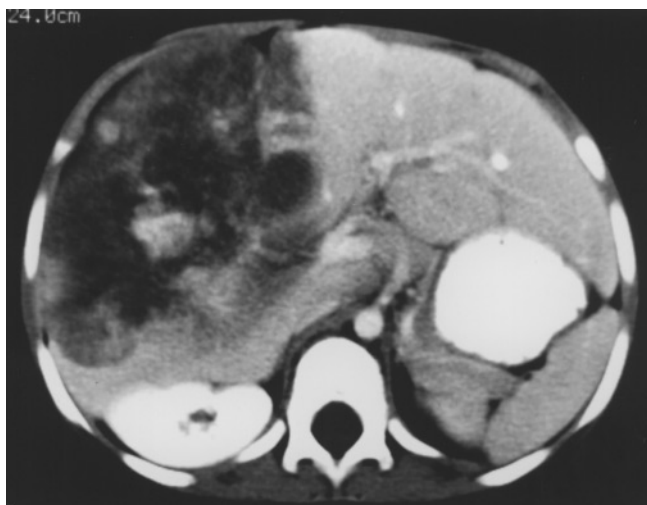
A: CT scan at diagnosis demonstrates a heterogeneous, partially enhancing mass involving the right lobe of the liver with extension into the medial segment of the left lobe. B: CT scan at optimal chemotherapeutic response shows marked reduction of tumor with involvement confined to the right lobe.
